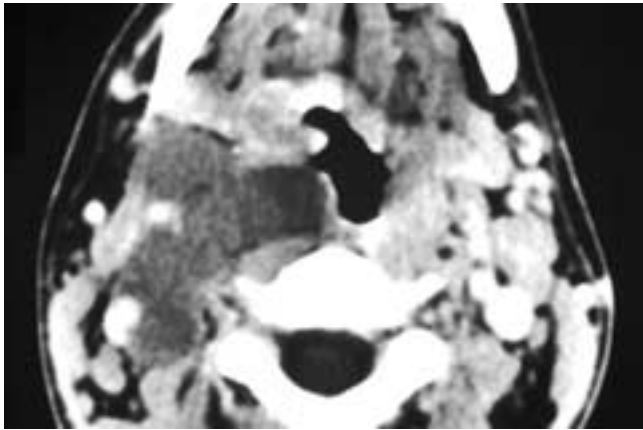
Axial contrast-enhanced CT scan shows a multiloculated cystic mass in the right parapharyngeal space. Although no cyst wall is clearly identified, this cystic lymphangioma (hygroma) remains clearly differentiated from the adjacent soft tissues.
